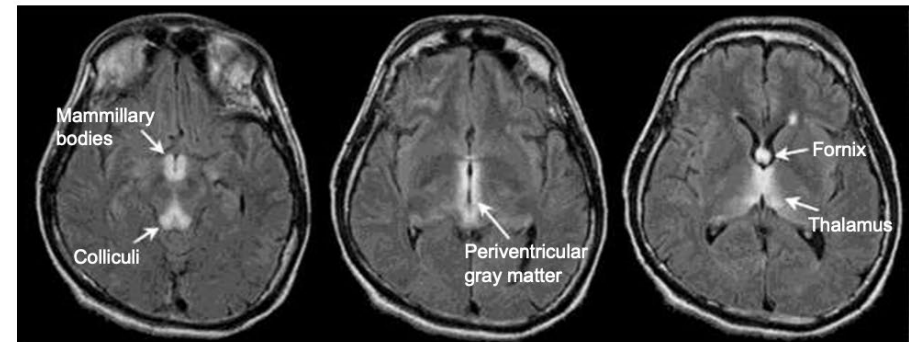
Three fluid-attenuated inversion recovery (FLAIR) images (5 mm thick with a 2.5 mm skip) of a 35-year-old man with schizophrenia and acute nutritional deficiency-induced Wernicke encephalopathy (WE). Note the hyperintense signal in the characteristic loci for WE pathology. Reproduced with permission from Sullivan & Pfefferbaum,⁷² © 2008 Sullivan & Pfefferbaum, Department of Psychiatry & Behavioral Sciences, Stanford University, Stanford, CA, USA.
